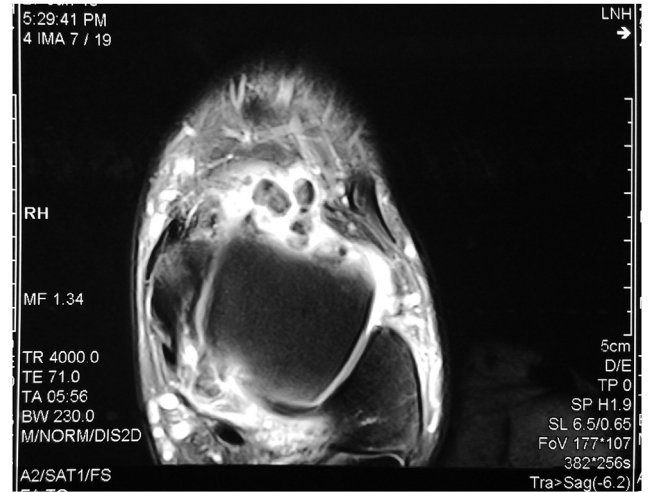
MRI of the left ankle – axial view.
